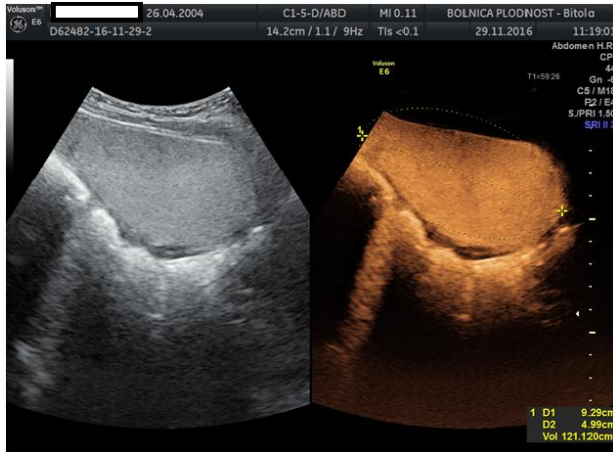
Contrast-enhanced voiding ultrasonography. Bladder filled with ultrasound contrast agent (B-mod "grayscale", left and B-mod + contrast specific software (right)
